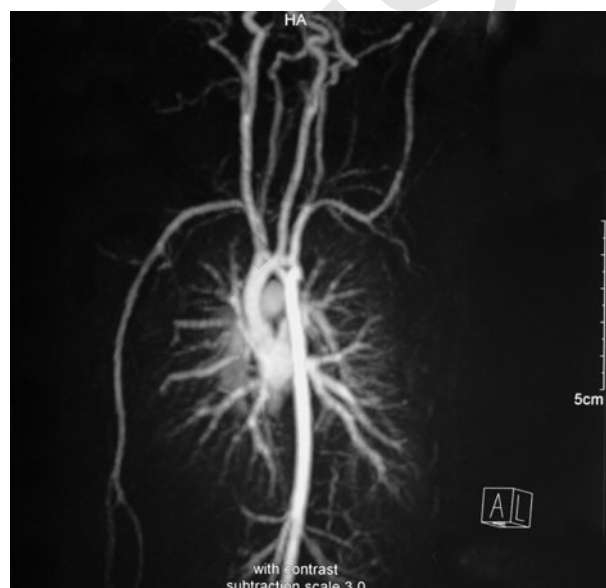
Magnetic resonance imaging in left anterior oblique projection in a patient with double aortic arch. Both aortic arch segments are of equal calibre and widely patent.
